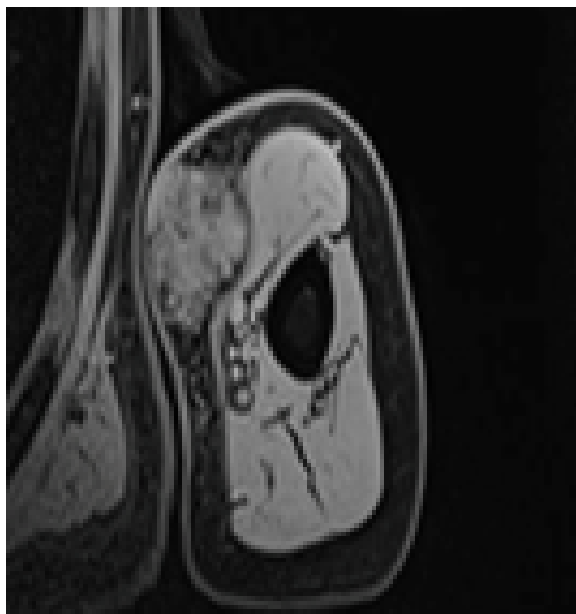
MRI of Left Upper Extremity W/WO.
